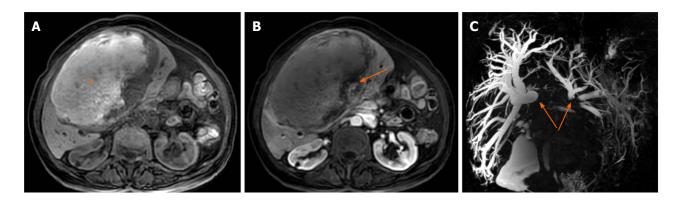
Magnetic resonance imaging showing a large, central, T1-hyperintense hepatic lesion. A: Blood products (asterisk); B: Arterial enhancement of the solid component (arrow); C: Magnetic resonance cholangiogram showing dilation of the intrahepatic bile ducts.
